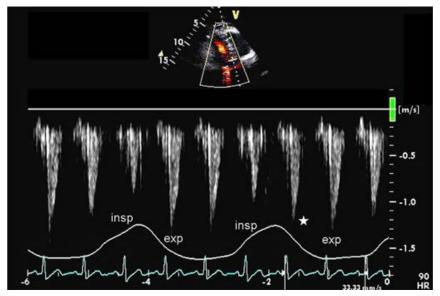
PW Doppler recording of LV outflow tract velocity in a patient with cardiac tamponade and pulsus paradoxus. On inspiration (insp), peak LV outflow tract velocity and ejection time decrease, with the opposite changes seen on expiration (exp). Note that there is a beat with an intermediate value during the second respiratory cycle (star) but not the first, reflecting that the dynamic relation between the cardiac heart rate and respiratory cycle. The LV outflow tract velocity changes occur as a result of respiratory changes in LV filling.
